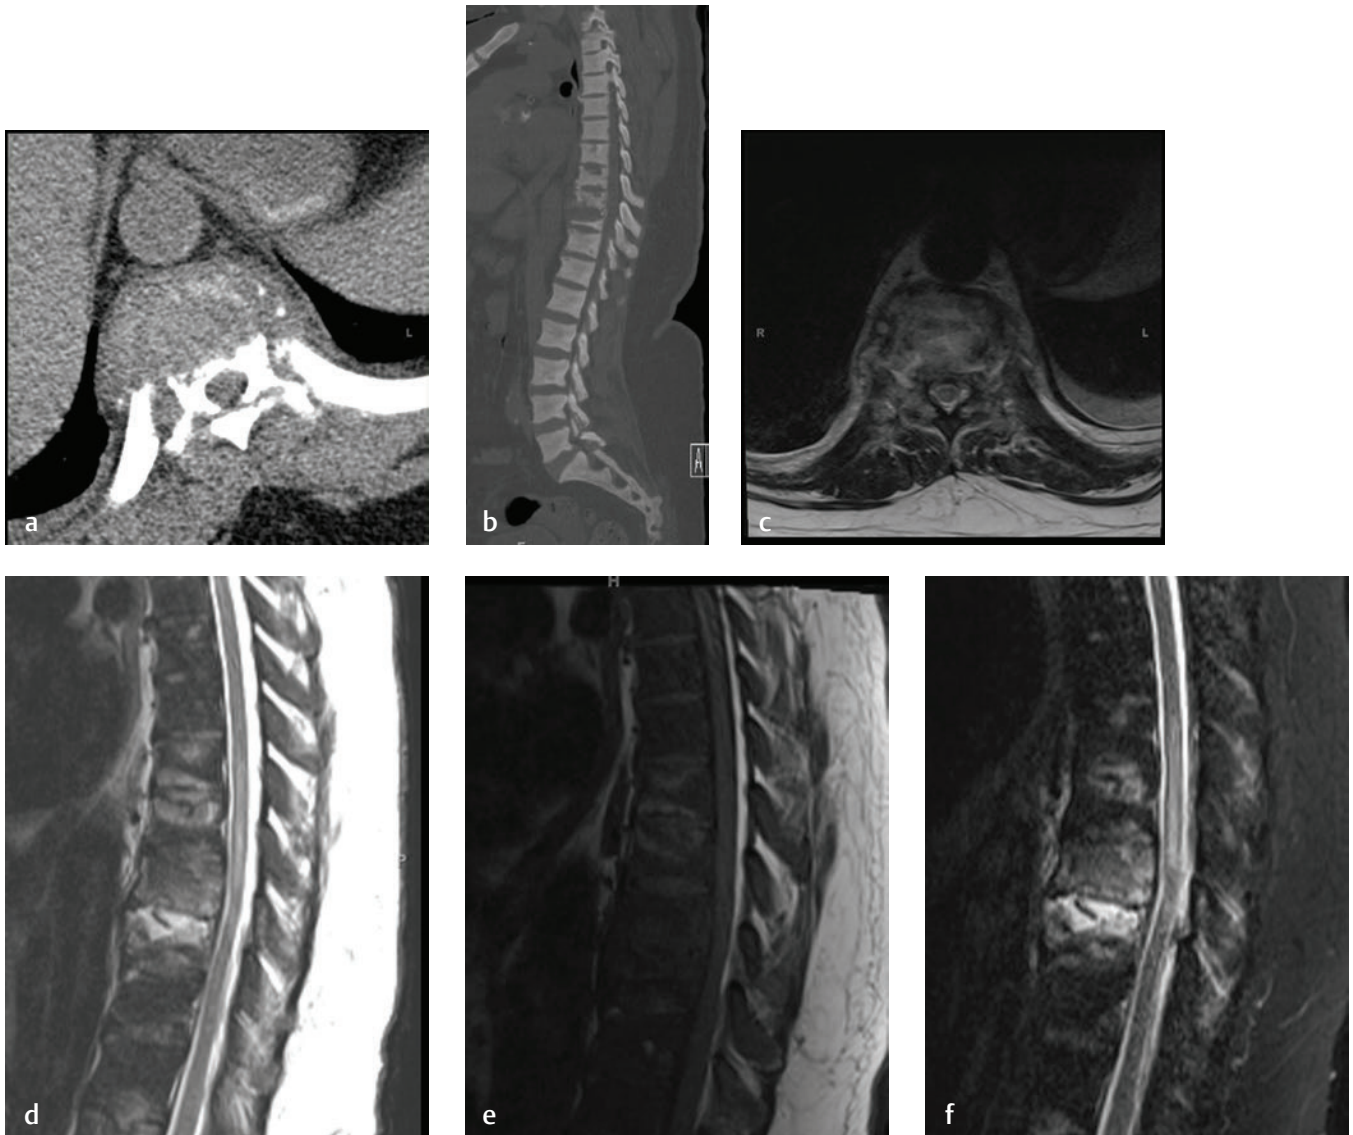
CT: evaluation of axial skeleton. Noncontrast CT was obtained in a patient on hemodialysis with septicemia and acute onset bilateral lower extremity paralysis. Initial radiographs were not helpful because of the patient's body habitus. (a) An axial CT image in a soft-tissue window reveals a paravertebral soft-tissue mass. (b) A sagittal CT image shows diffuse spine sclerosis with end-plate destruction in the lower thoracic spine. The constellation of clinical and imaging findings suggested discitis and osteomyelitis. (c) An axial T2-weighted image shows bilateral paravertebral extension, whereas (d) the sagittal T2-weighted image shows intramedullary cord edema in addition to frank fluid signal in the affected intervertebral disc space. (e) A sagittal T1-weighted image shows diffusely hypointense or dark vertebral bodies, whereas (f) the sagittal STIR image accentuates the fluid signal in the affected intervertebral disc. The constellation of findings suggested a diagnosis of infection. The patient underwent percutaneous CT-guided biopsy, which confirmed discitis and osteomyelitis.
